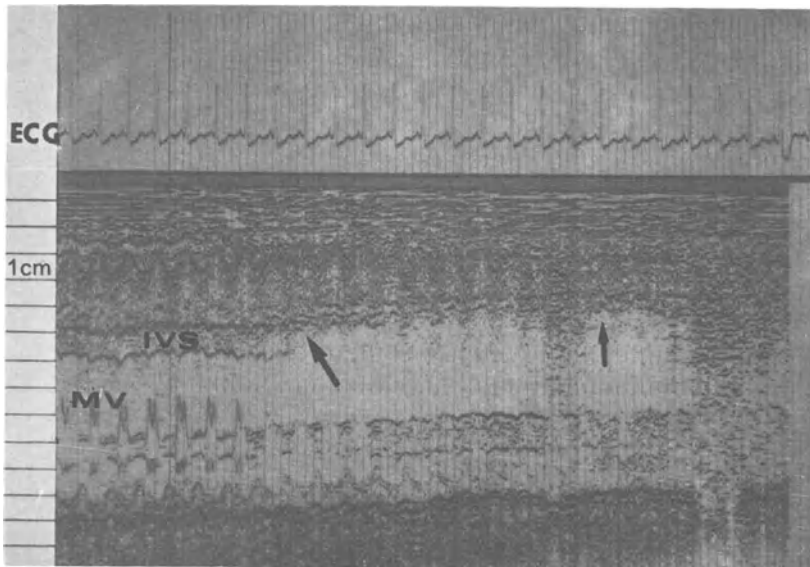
An M-mode echocardiogram from a patient with a large antero-septal myocardial infarction. Thickening of interventricular septum is increased. (arrows).
